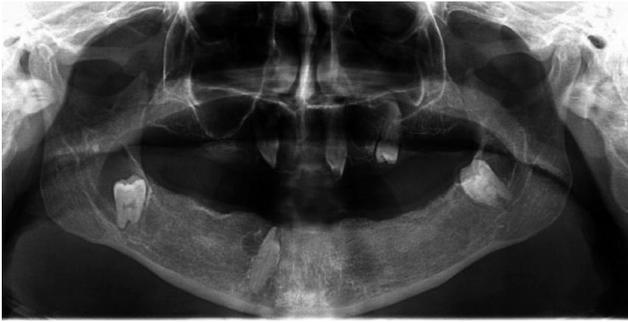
Panoramic radiograph showing multiple impacted teeth in both jaws and follicular enlargements around teeth in the mandible
